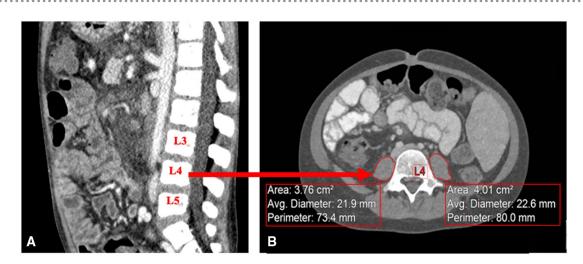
Measurement of PMSA. (A) Midline sagittal CT abdominal image demonstrates the lumbar vertebrae, including L4; (B) the corresponding level is then located on the axial image allowing for PMSA measurement.
